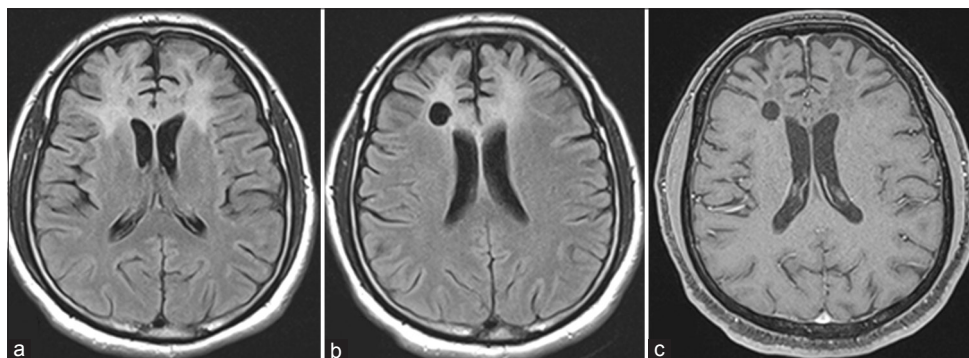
(a) Serial magnetic resonance imaging at 4th month of follow-up showing persistence of fluid-attenuated inversion recovery (FLAIR) hyperintensity with early overlying bifrontal atrophy; (b) FLAIR image at 1 year of follow-up demonstrating marked reduction in hyperintensity and significant atrophy; (c) T1-weighted gadolinium-enhanced image at 1 year showing no contrast enhancement in contrast to Figure 1b and c
